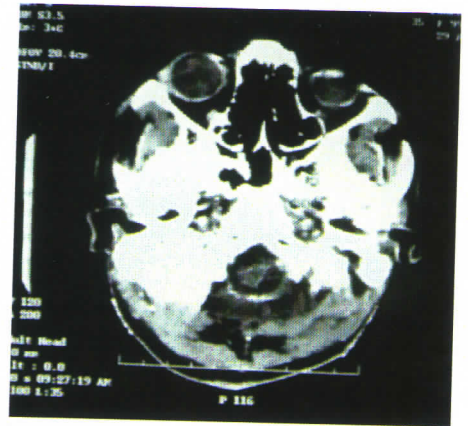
b : Post op CT scan after midline posterior suboccipital approach showing no residual tumor.
